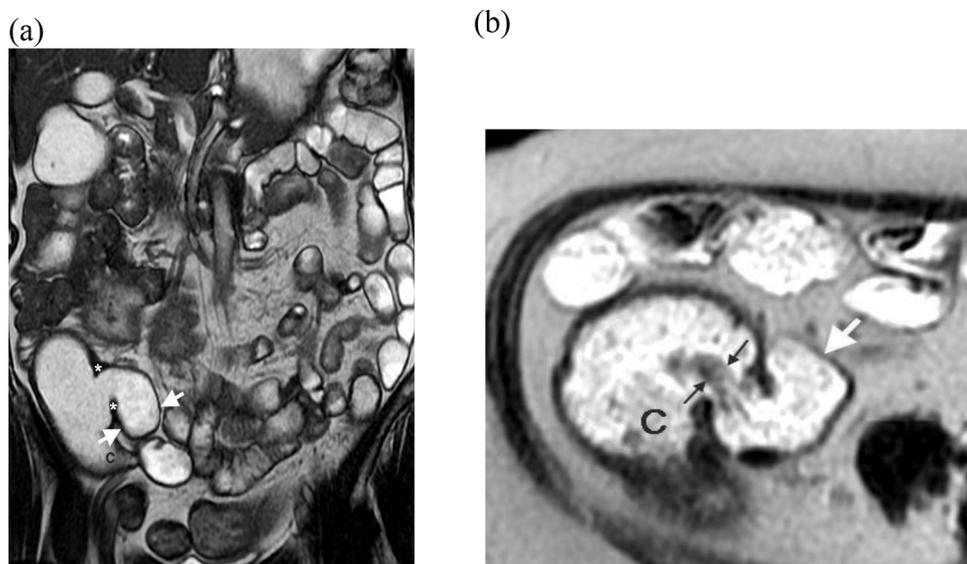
A 62-year-old woman with BWI. A, Coronal SSFP and B, Axial T2 - weighted SSFSE MR image show widely patent ICV orifice and dilated terminal ileum (arrows). Asterisks on A, indicate atrophic ICV lips allowing free reflux of colonic contents into the ileum. Note absence of wall thickening in terminal ileum. Regurgitant flow (black arrows on B) originated from cecum (C) and directed toward terminal ileum lumen through ICV orifice can be seen.
